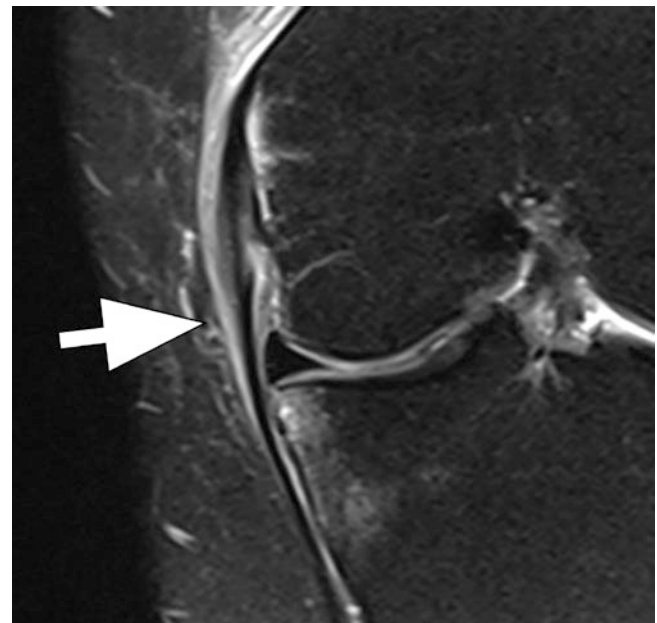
Grade II MCL tear. Coronal T2-weighted image with fat suppression. Increased signal and thickening of the MCL (arrow)
